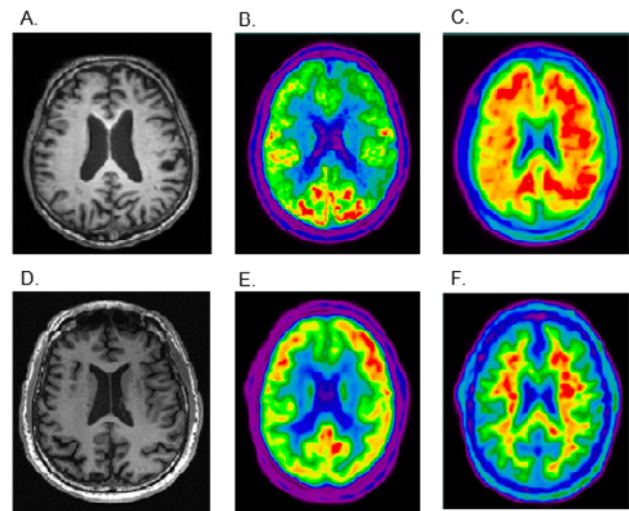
Axial MRI (A,D), [18F]-fluorodeoxyglucose PET (B,E) and [18F]-florbetapir PET (C,F) in two different people; top row: decreased [18F]-fluorodeoxyglucose in the parietal, temporal (not shown), and frontal lobes (B) as well as increased [18F]-florbetapir in the cerebral cortex (C) are characteristic of Alzheimer's disease; bottom row: normal radiopharmaceutical uptake (E, F) (11).
